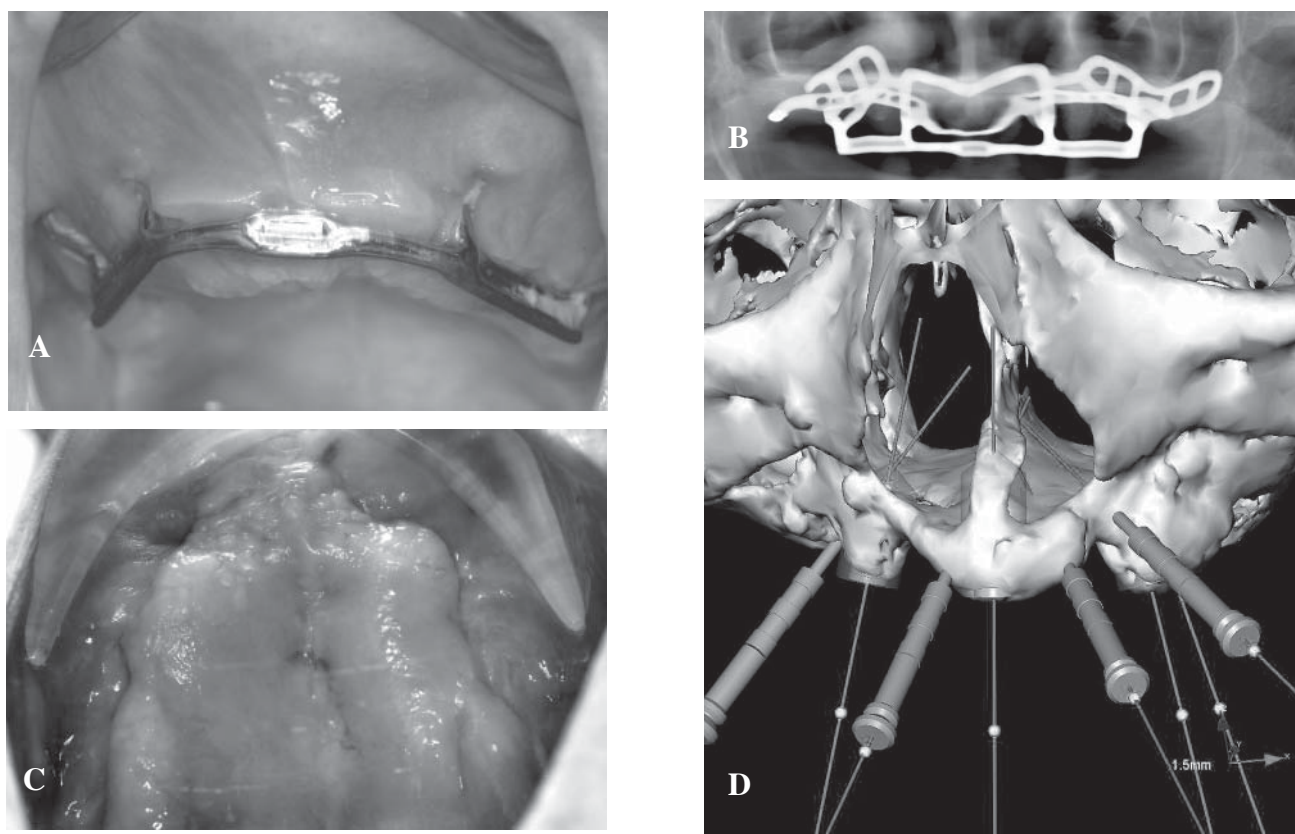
79-year-old female with severe degeneration of the maxilla secondary to a long standing maxillary subperiosteal implant that resulted in chronic and acute infections, sinusitis, and sinus perforations. The subperiosteal implant was removed prior to the CT scan. A. Subperiosteal implant in place in maxilla, B. Preoperative radiograph, C. Maxillary ridge, after removal of the subperiosteal implant, prior to implant placement, D. CT scan image (NobelProcera®) after implants were virtually placed.
